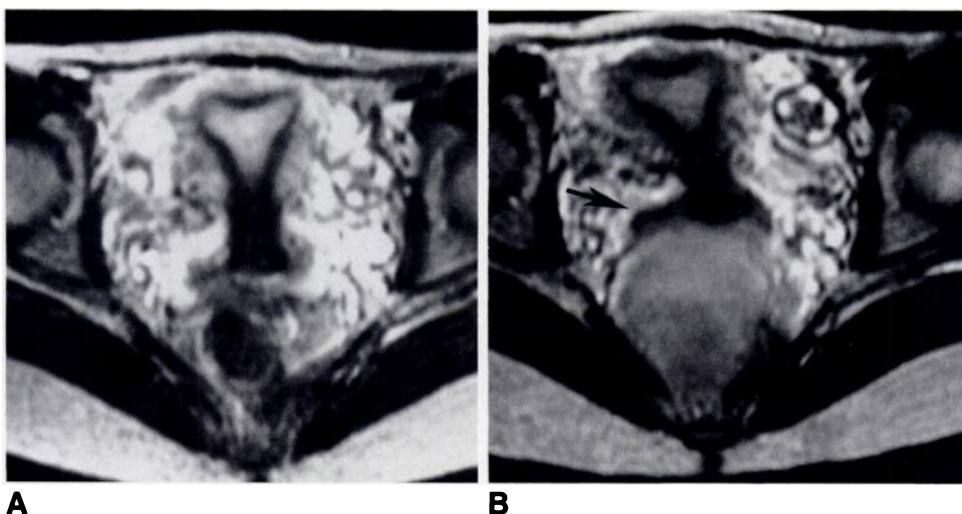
Axial T2-weighted MR images of uterus.
